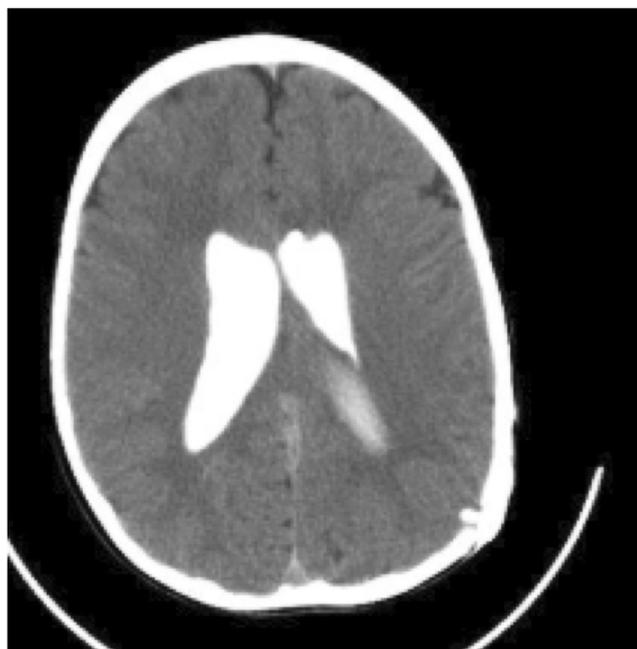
CT study dye study showing enlargement of the ventricles at a time when the ventricular catheter failed but the catheter in the cortical subarachnoid space continuing to function selectively draining the cortical subarachnoid space
